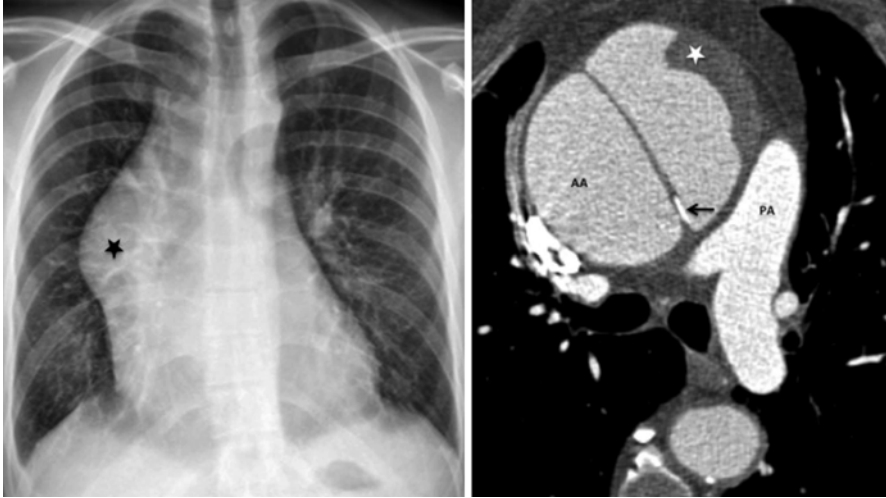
A 60-year old female hypertensive with known aortic aneurysm presented with acute severe chest pain radiating to the back. Dilated ascending aorta (*black star*) on the chest radiograph (*left panel*). Axial CT (*right panel*) shows the ascending aortic (AA) aneurysm with a dissection flap and displaced calcification (*black arrow*) and antero-lateral thrombus (*white star*). Also note the compression and displacement of the pulmonary artery (PA)
